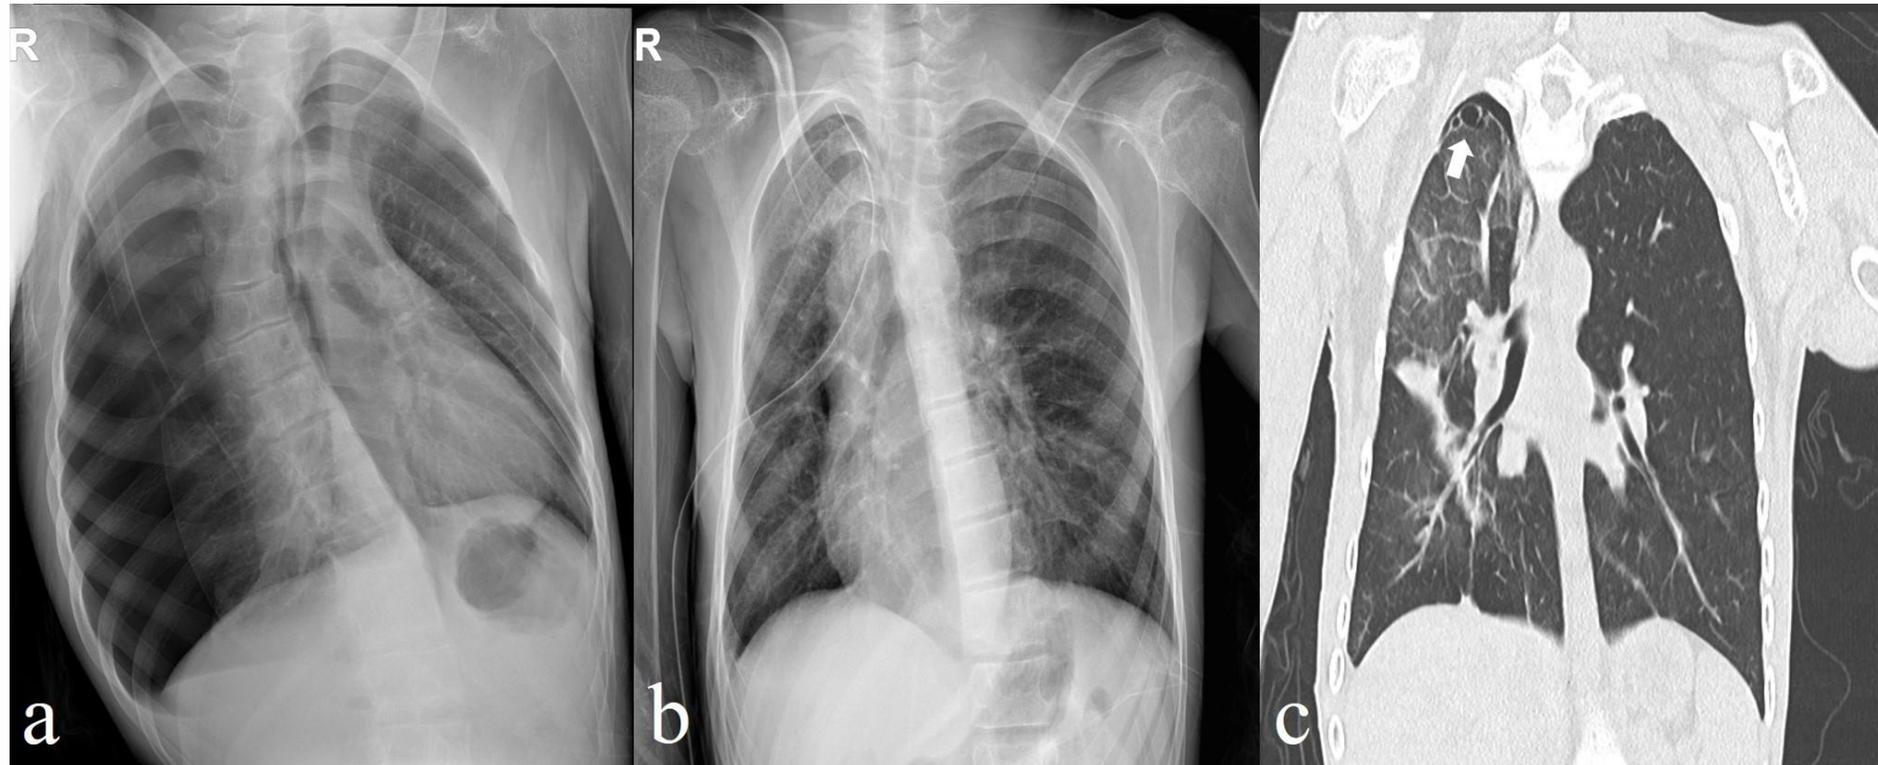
Preoperative imaging studies: (A) Sizeable right-sided pneumothorax seen on chest X-ray; (B) Successful re-expansion of right lung following closed thoracostomy; and (C) Multiple bullae at apex of right upper lobe (white arrow) on computed tomography of chest (coronal view).
